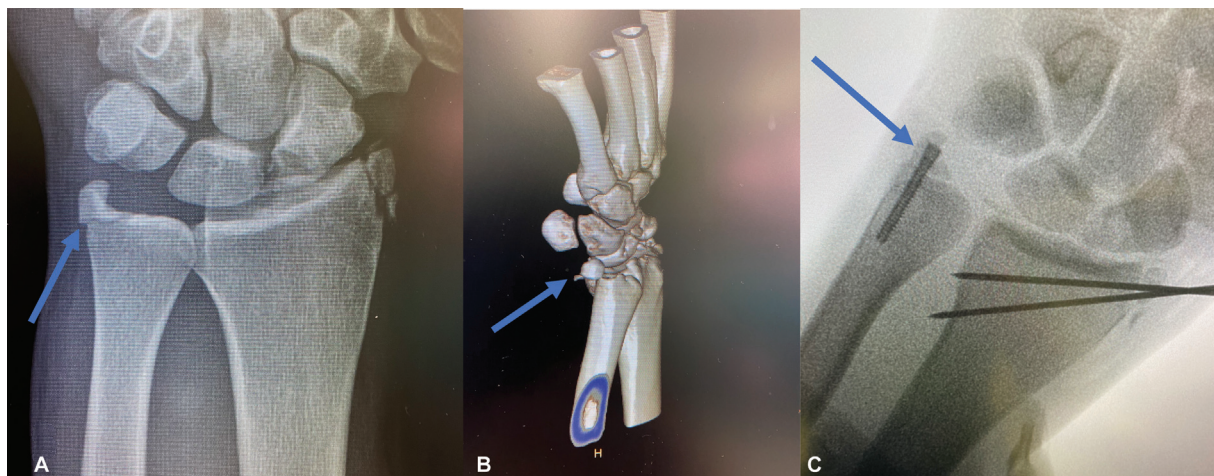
(A) Ulnar styloid base fracture (arrow). (B) Displaced ulnar styloid base fracture (arrow) on computed tomography (CT) reconstruction. (C) Headless compression screw for an ulnar styloid base fracture (arrow).
